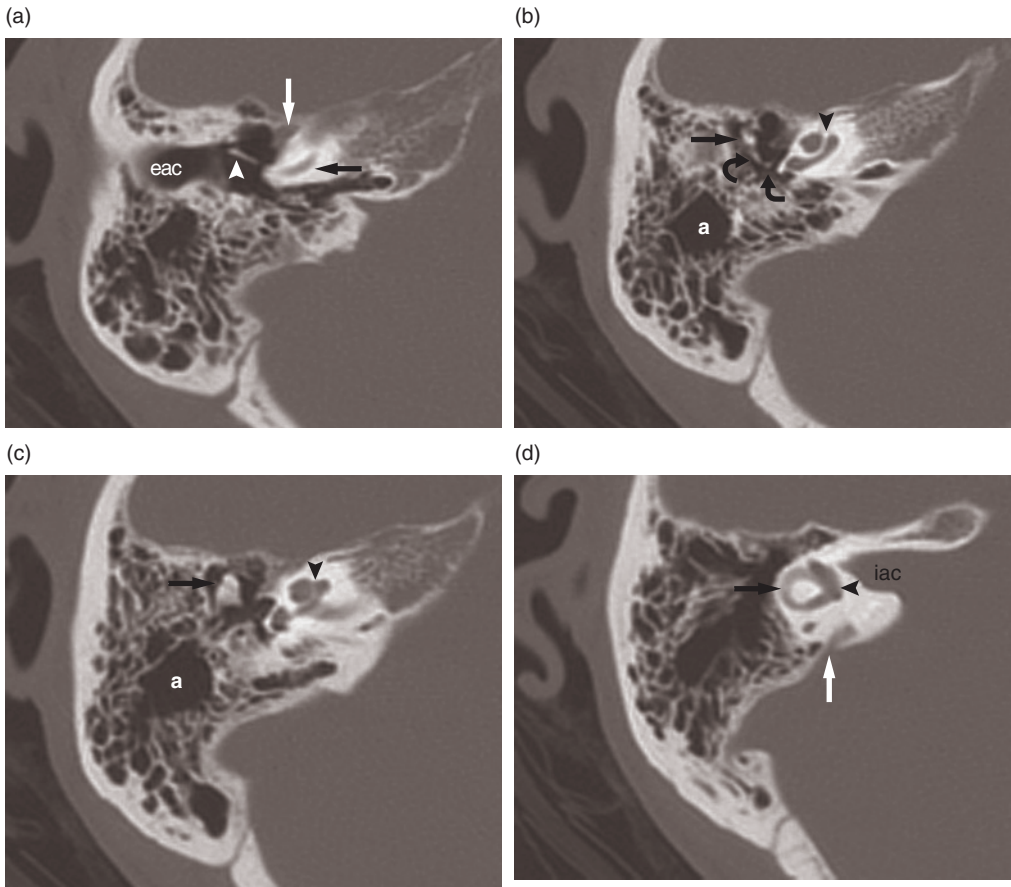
High-resolution CT of the right petrous bone: axial images. (a) External auditory canal (eac), malleus handle (arrowhead), tensor tympani (white arrow), basal turn of the cochlea (black arrow); (b) malleus head (straight arrow), incus (curved arrow), stapes (angled arrow), cochlea (arrowhead), mastoid antrum (a); (c) malleoincudal joint (arrow), cochlea (arrowhead), mastoid antrum (a); (d) vestibule (arrowhead), lateral semicircular canal (black arrow), vestibular aqueduct (white arrow), internal auditory canal (iac) ('b' and 'c' reproduced from Calzolari F., 2006,⁶ with permission of Omega Edizioni).
